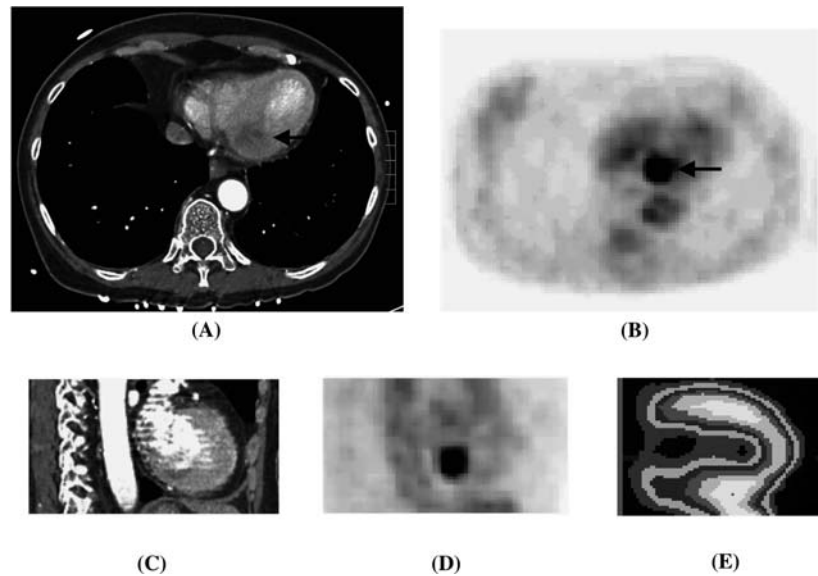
Contrast enhanced axial (A) and sagittal (C) multiplanar CT images show basal inferior subendocardial hypoenhancement without thinning (arrow). The respective F-18 FDG PET images (B and D) show intense uptake in the corresponding basal inferior region (black arrow), suggesting viable hibernating myocardium as confirmed by flow-metabolic mismatch on Tc-99m Sestamibi resting SPECT with severe basal inferior hypoperfusion (E).
